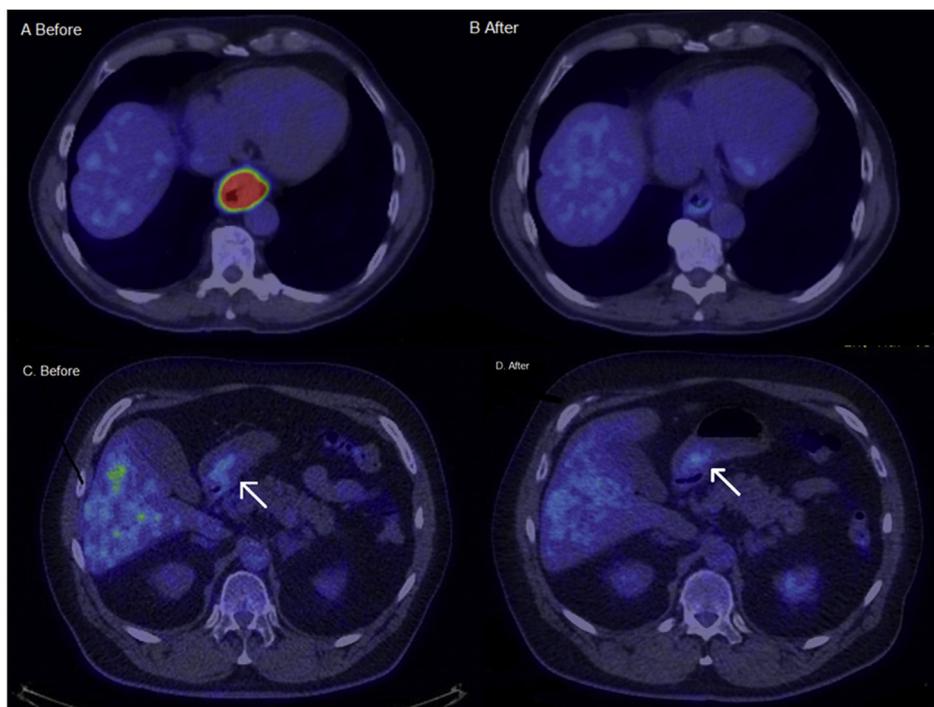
FDG-PET images from metabolic responders and non-responders. A. Distal esophageal carcinoma of intestinal type, SUV_{max} 21.9 B. Major metabolic response after two cycles of chemotherapy, SUV_{max} 4.5, $\delta SUV_{max}\%$ -79% C. Diffuse gastric carcinoma in antrum, SUV_{max} 4.4 D. Metabolic non-responder after two cycles of EOX treatment, SUV_{max} 4.4, $\delta SUV_{max}\%$ = 0.
